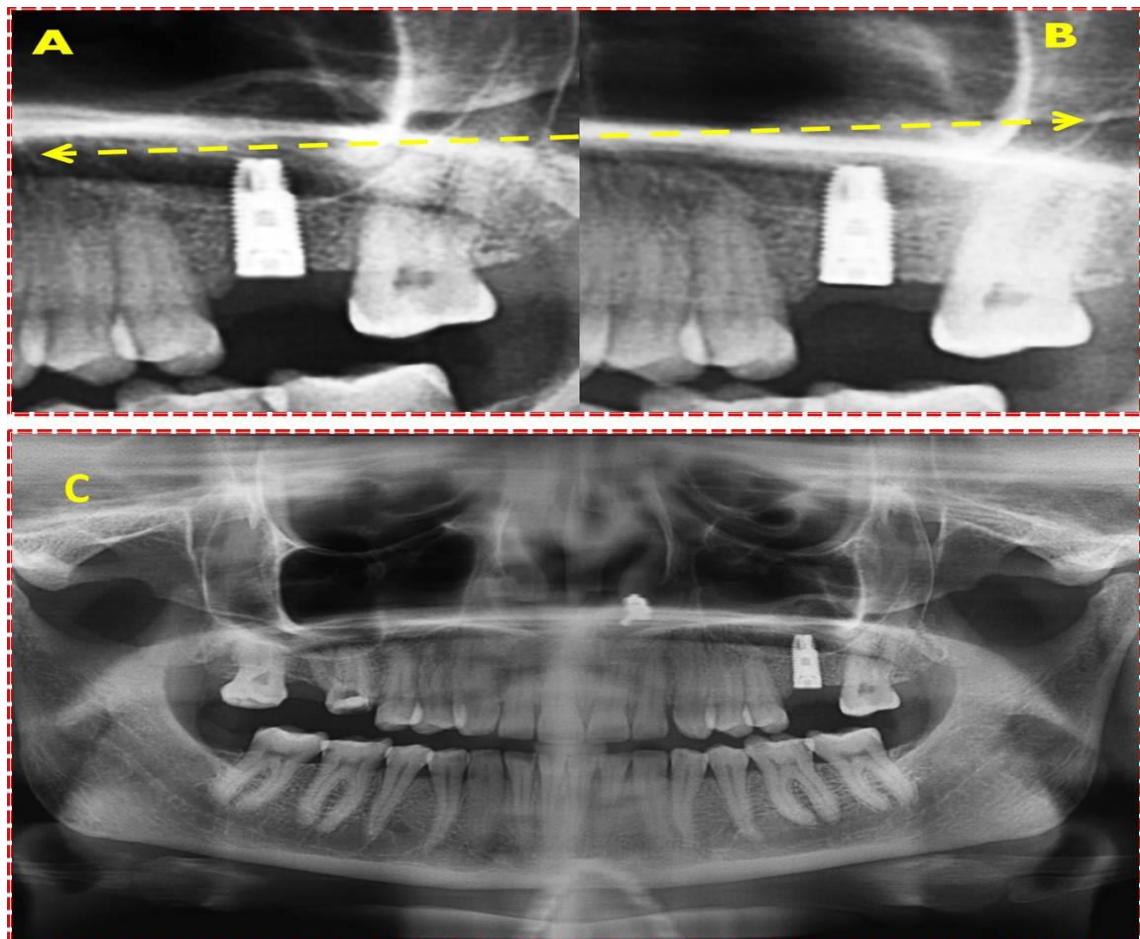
(A) Post-operative orthopantomograph (OPG) after sinus augmentation showing the differences between pre and post sinus augmentation bone levels in first molar region (B) OPG showing bone level gained before prosthodontic restoration.
